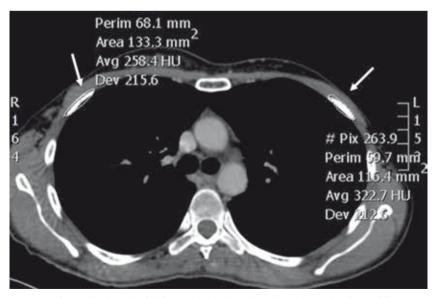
Regions of interest were performed in thoracic CT, for evaluating bone density, where a significant difference was found in left versus right thorax, indicating reduced bone mineral density in left thoracic ribs, result of the previous radiotherapy for left breast cancer therapy. The same method was used for evaluating lung parenchyma for lung injury; however, no significant difference was found (not shown), thus excluding radiation-induced fibrosis in the heavily irradiated lung parenchyma [9, 10]
